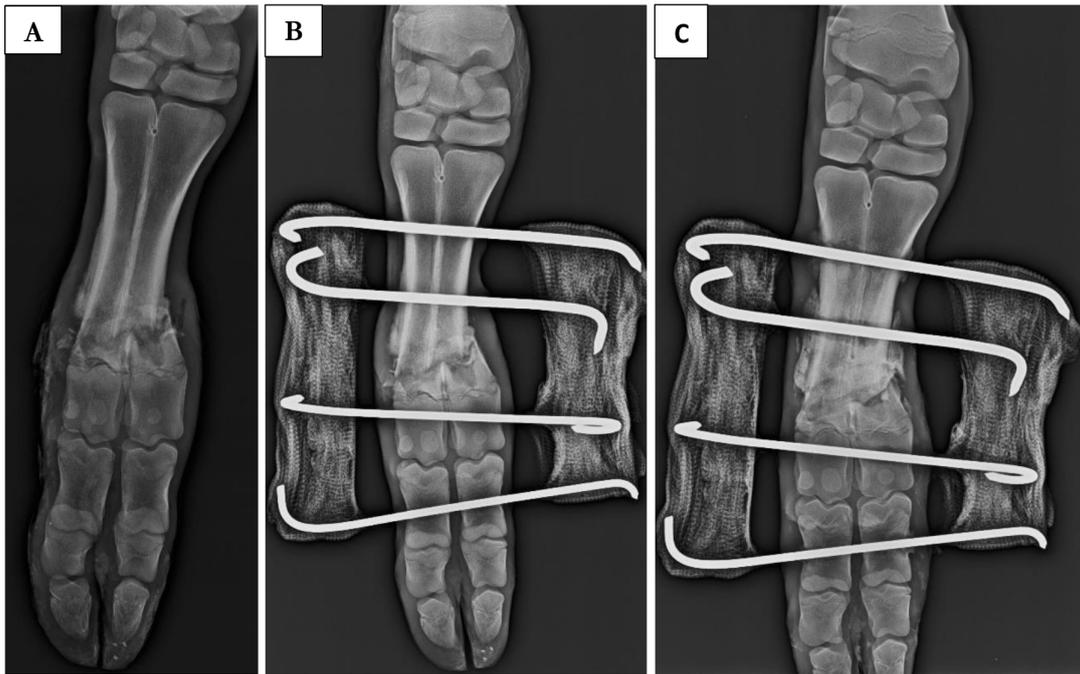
Treatment stages of an infected open distal diaphyseal metacarpus fracture of a case A: Preoperative radiographic image of the fracture B: Postoperative day 0 radiograph C: Postoperative 28th day radiograph
